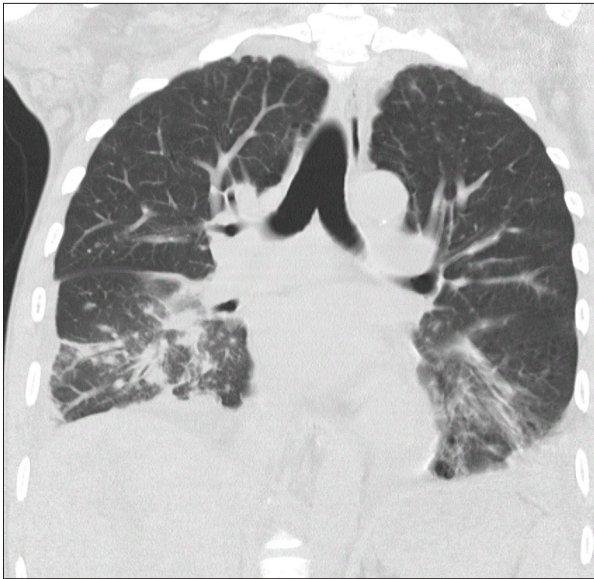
Coronal image of initial CT of the chest shows various parenchymal abnormalities, including small areas of ground-glass infiltrates in the lingual and RLL. There is significant peribronchial thickening and diffuse nodularity of the bronchovascular bundles, suggestive of pulmonary Kaposi sarcoma.
